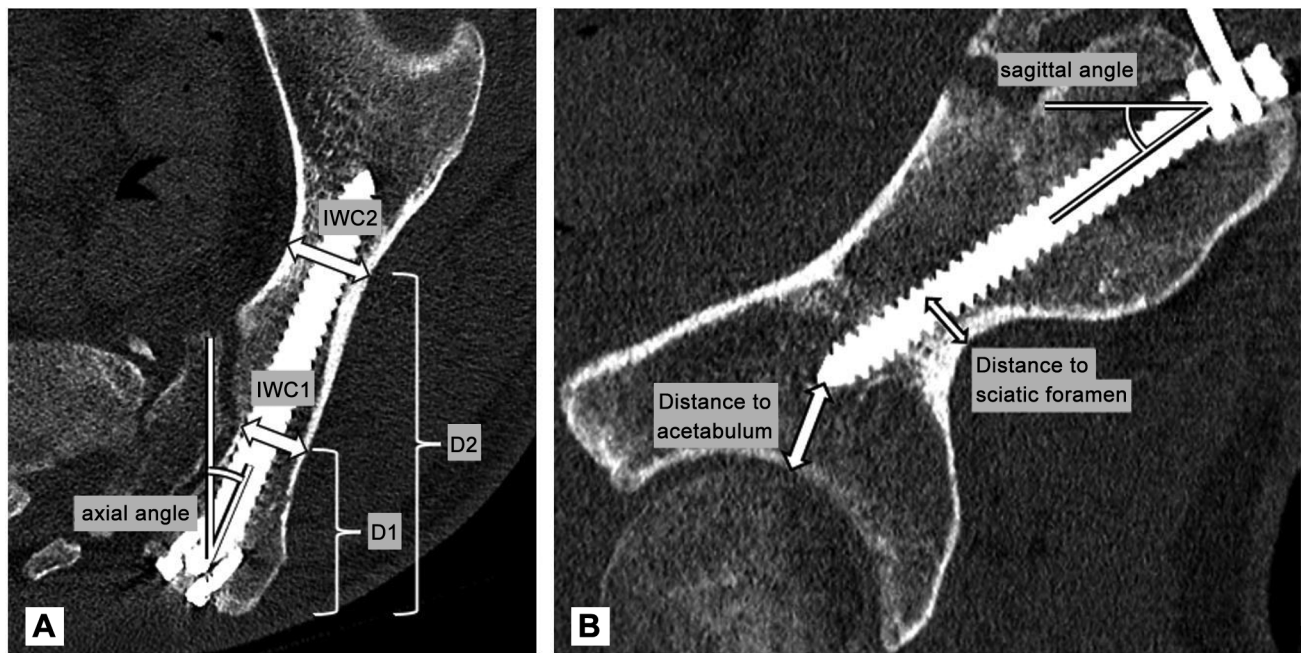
Computed tomography (CT) imaging following iliac screw placement. The iliac screw is demonstrated in the axial plane (A) and sagittal plane (B). Anatomic landmarks described in Table I are highlighted. Besides described anatomic landmarks, it can also be seen that the screw head is beneath the most posterior prominence of the posterior superior iliac spine (PSIS), which is clinically important to reduce symptomatic implant prominence.
